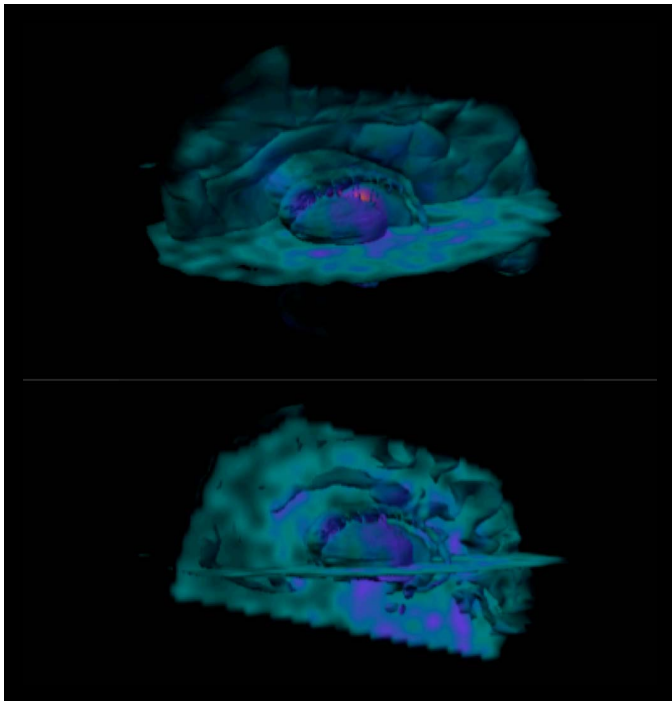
Volumetric embedded deep brain structure visualization in SPECT functional imaging. Note the difference in camera position, one of the basic features that allow interaction with the brain structures.
